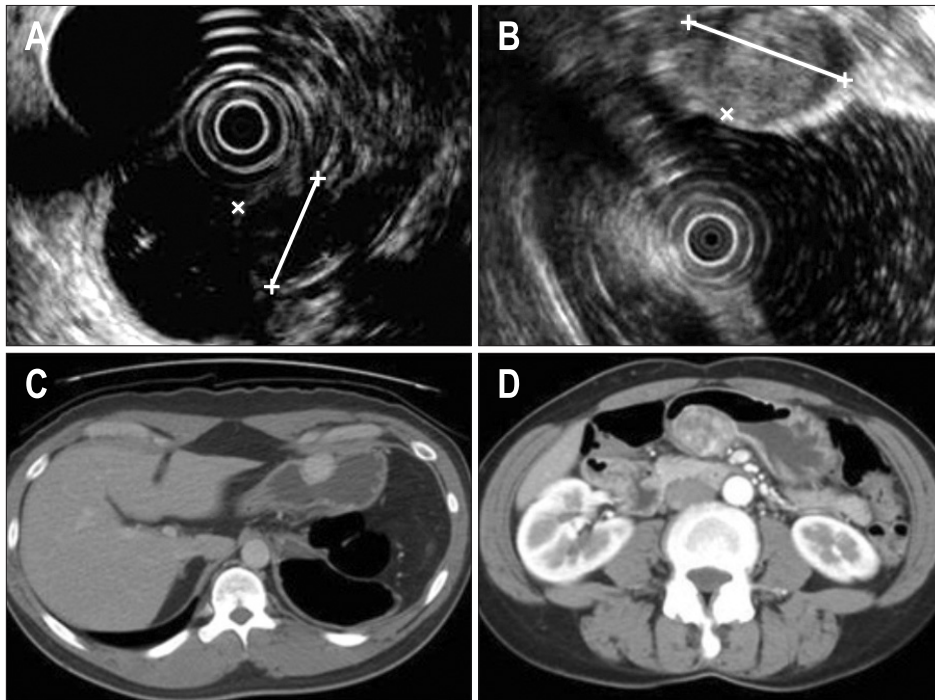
(A) Endoscopic ultrasonography in case number 4 shows a hypoechoic mass. (B) Case number 9 shows heterogeneous echogenicity due to internal hemorrhage and calcification. (C) A computed tomography (CT) scan demonstrates a homogeneously enhanced ovoid mass in the anterior wall of the stomach. Perigastric fat infiltration or lymph node enlargement was not noted. (D) The CT scan of case number 9 reveals a heterogeneously enhanced mass in the posterior wall, which may have been caused by hemorrhage or necrosis.
